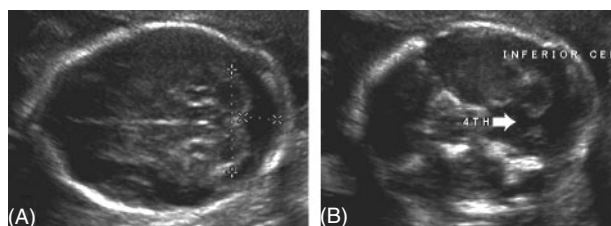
Prenatal ultrasound of affected fetus (Case 1) at 21 weeks' gestation. (A) Superiorly, the midline cerebellum appears intact. (B) Inferiorly, an apparent connection between the 4th ventricle and cisterna magna is present (white arrow)
